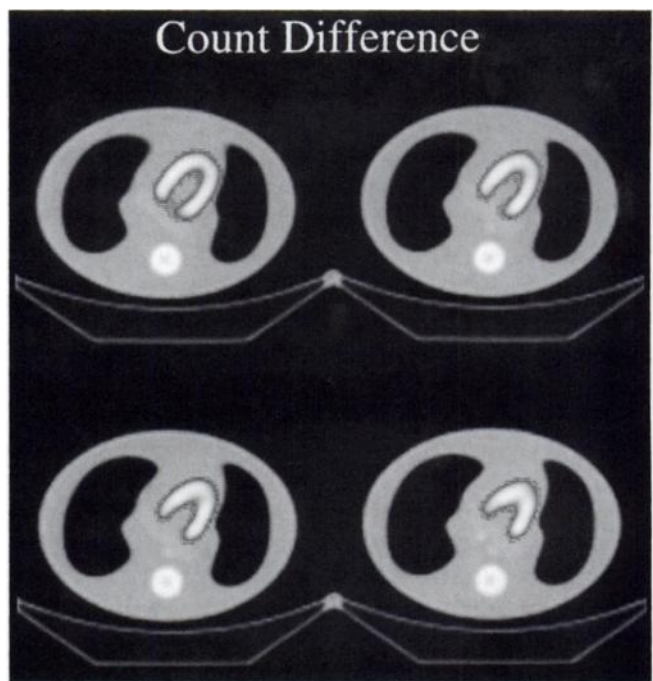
Transverse slices of SPECT images, registered using count difference, overlaid on CT images.
